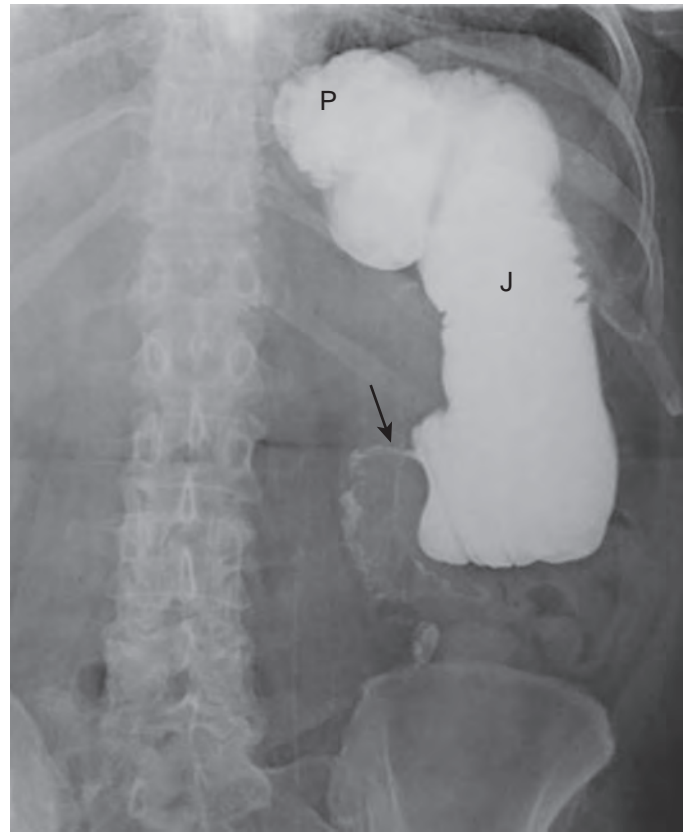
Obstruction of the alimentary limb following RYGB caused by JJ stomal stenosis. An overhead radiograph from UGI shows a dilated gastric pouch (P) and jejunal Roux limb (J) (alimentary limb) extending toward an abrupt transition at the JJ anastomosis (arrow) caused by stomal stenosis and fibrosis.
